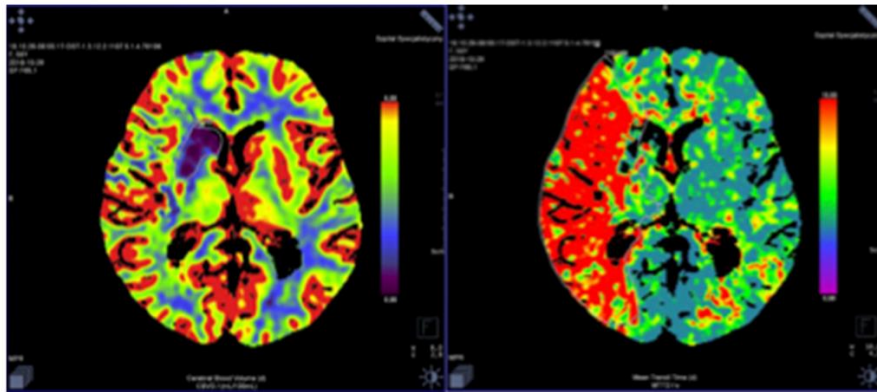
Brain perfusion in computed tomography. Cerebral blood volume (CBV, left) and mean transit time (MTT, right) maps. The area of severely reduced CBF (<30% of that in normally perfused tissue) with reduced CBV represents the “ischemic core”; the region of perfusion delay of >6 s
